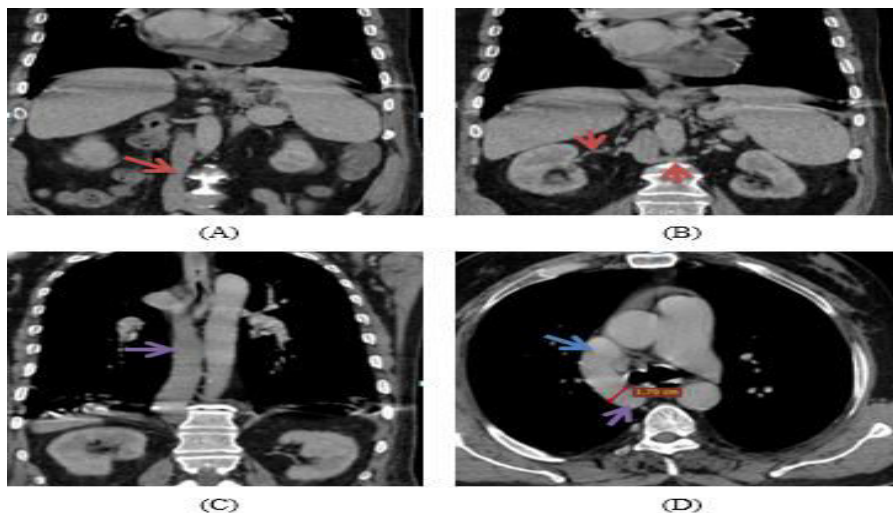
30-year-male patient presented to our department complaining of abdominal pain.(A) Coronal CT image showing infrahepatic portion of IVC (orange arrow).(B) Coronal CT image showing right and left renal veins draining to IVC (orange arrows).(C) Coronal CT image showing azygos vein as a continuation of IVC in the chest (arrow).(D) Axial CT image showing azygos vein, which is dilated measuring 17 mm (arrow) draining into SVC (blue arrow). CT picture suggesting: Intrahepatic interruption of IVC with azygos continuation.
